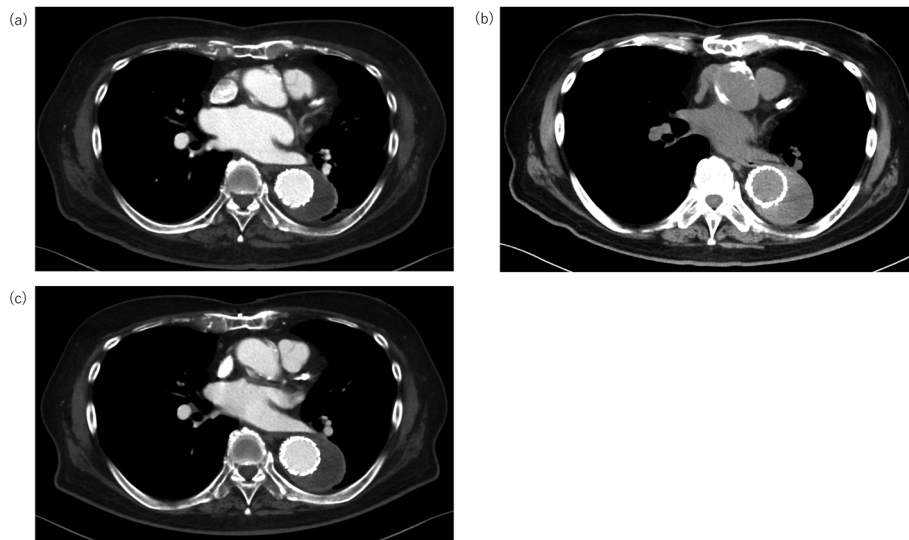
Computed tomography showed a descending aortic aneurysm (Th7/Th8 level). (a) Enhanced computed tomography at 3 days after admission (maximum diameter was 61 mm). (b) Computed tomography at 32 days after admission (maximum diameter was 63 mm). (c) Enhanced computed tomography at 54 days after admission (maximum diameter was 61 mm).
